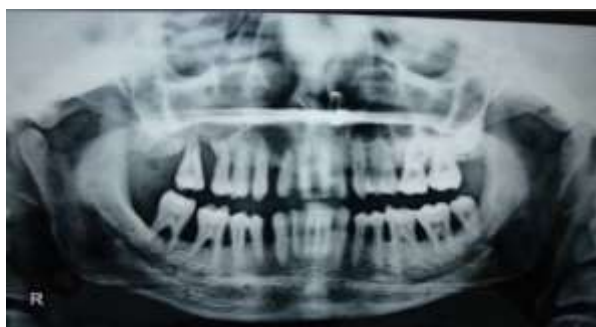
Panoramic radiographic view showing generalized severe bone loss
